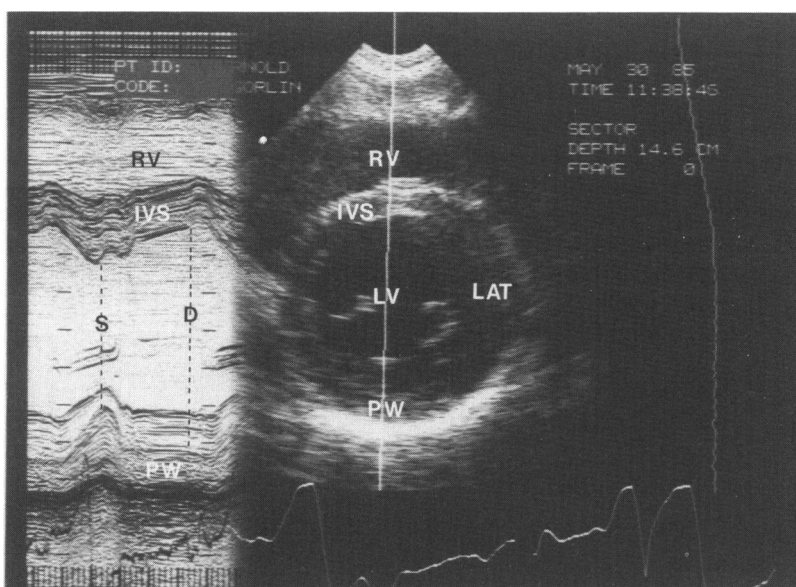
Short access view—papillary muscle level. On the right is seen a short axis view at the level of the chordae and papillary muscle. An entire circumferential cross-section of the ventricle is seen in this view: the interventricular septum (IVS), the lateral wall (LAT), and the posterior wall (PW). On the left is the M-mode echocardiogram taken from the M-mode beam seen on the two-dimensional echocardiographic cut. Ventricular filling and contraction can be seen, represented as the smaller cavity during systole (S) and the larger cavity during diastole (D).
